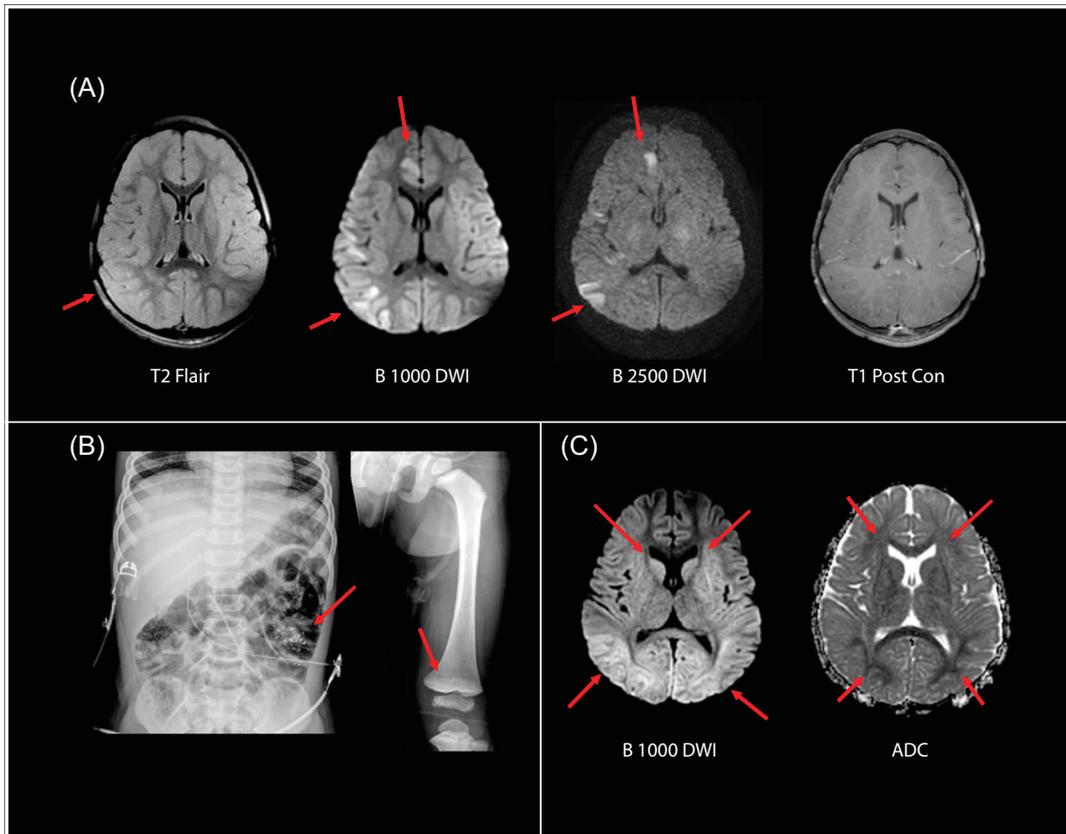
(A) MRI of the brain on day of admission shows T2/FLAIR hyperintensity with diffusion restriction in the right posterior occipital cortex, with additional diffusion restriction in the right occipital and perisylvian cortex as well as medial right frontal lobe, consistent with acute injury (red arrows). No enhancement was noted. (B) Skeletal survey shows no acute fracture. There is radiopaque material mixed with the stool in the left lower quadrant (red arrow, left) on abdominal radiograph, suggesting ingestion of a foreign substance. Long-bone radiograph shows lead lines with increased opacification at the metaphases (red arrow, right). (C) Repeat MRI of the brain 4 days after admission shows additional diffusion restriction on DWI/ADC maps within the bilateral occipital cortices, basal ganglia, periventricular white matter and corpus callosum, compatible with a combination of lead toxicity, evolving hypoxic ischemic injury, and possible superimposed postictal changes (red arrows). ADC, apparent diffusion coefficient; DWI, diffusion weighted imaging; MRI, magnetic resonance imaging.
